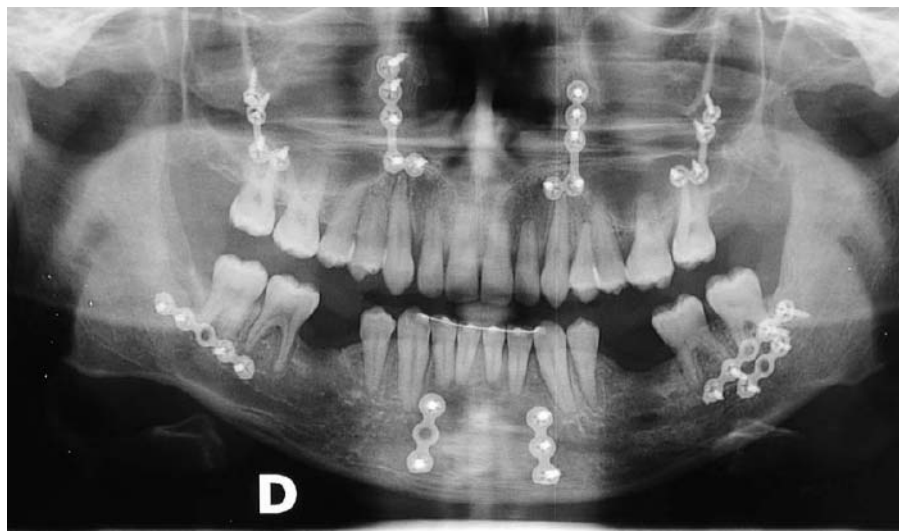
Radiographic image after the orthognathic surgery for a second skeletal class.
